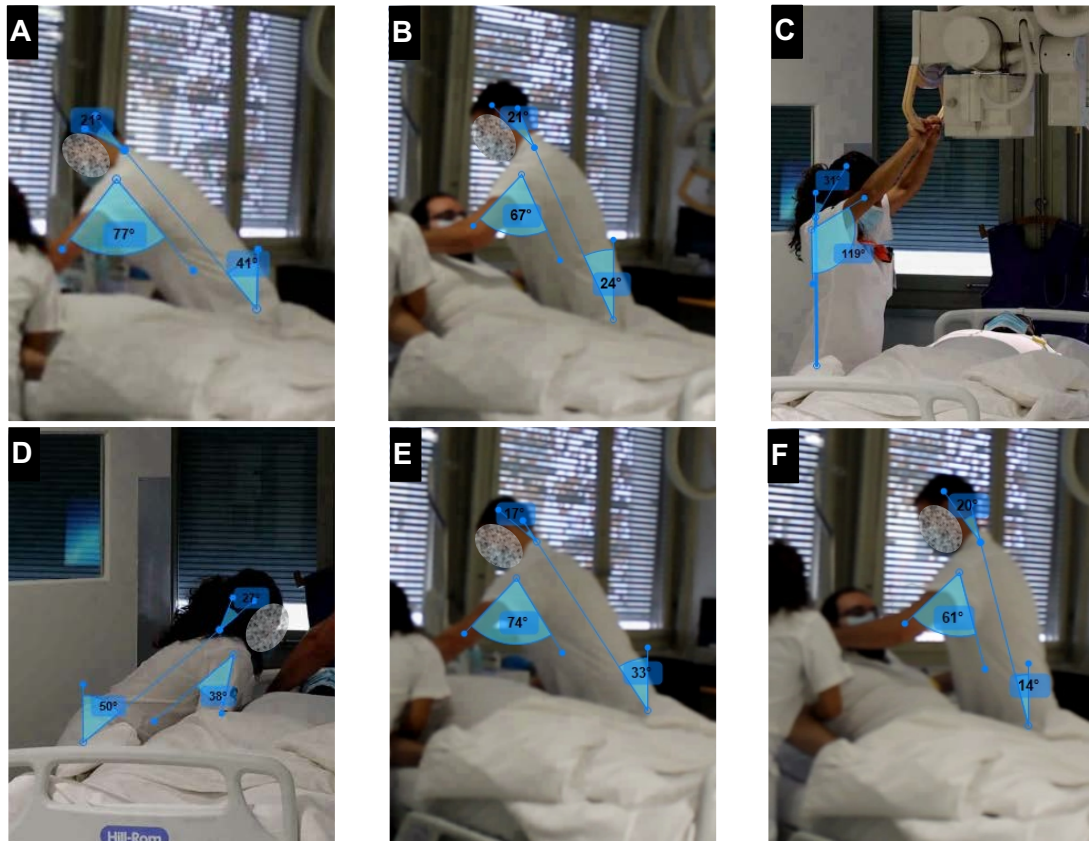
"Not acceptable" postures assumed by the shorter (performer) and taller (helper) radiographers during bedside chest X-ray examination in scenario 5: a) the taller radiographer during the preparation to position the detector under the patient's back; b) the taller radiographer during the patient handling to position the detector under the patient's back; c) the shorter radiographer during the X-ray tube positioning; d & e) the shorter and taller radiographer during the preparation to remove the detector from under the patient's back; f) the taller radiographer during the patient handling to remove the detector from under the patient's back.
